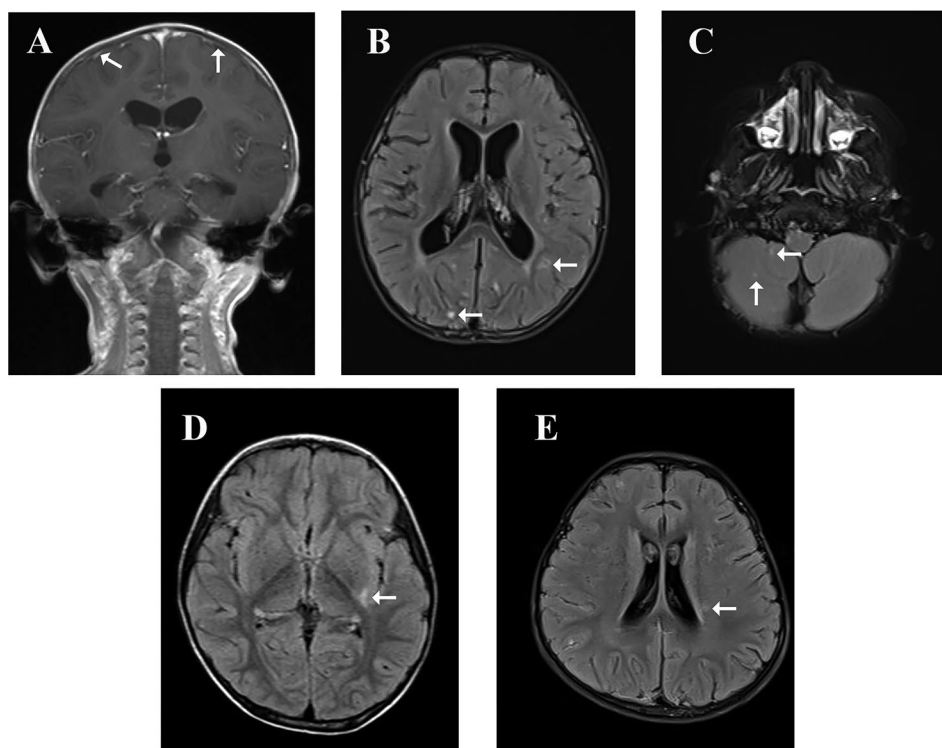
Brain MRI findings in patients with *A. cantonensis*. (A) coronal T1-weighted MRI showing leptomeningeal nodular enhancement after gadolinium injection. (B) Axial T2-weighted Flair MRI showing hyperintense lesions in the subcortical and deep white matter of the posterior parieto-occipital region. (C) Axial T2-weighted Flair MRI showing hyperintense lesions in cerebellum. (D) Axial T2-weighted Flair MRI showing hyperintense lesions in basal ganglia. (E) Axial T2-weighted Flair MRI showing hyperintense lesions in white matter around the left lateral ventricle
